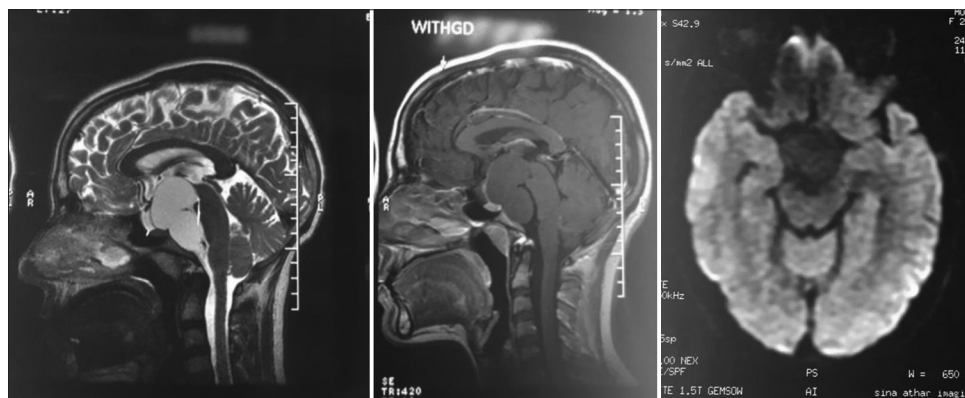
Preoperative magnetic resonance imaging. The T2-weighted sagittal image (left) shows a large hyperintense retroclival cystic mass extending into interpeduncular and suprasellar cisterns, causing compression and posterior displacement of brain stem. The T1-weighted postgadolinium sagittal image (middle) shows a nonenhancing mass. Diffusion weighted image (right) demonstrates a mass lesion in interpeduncular cistern without restricted pattern
